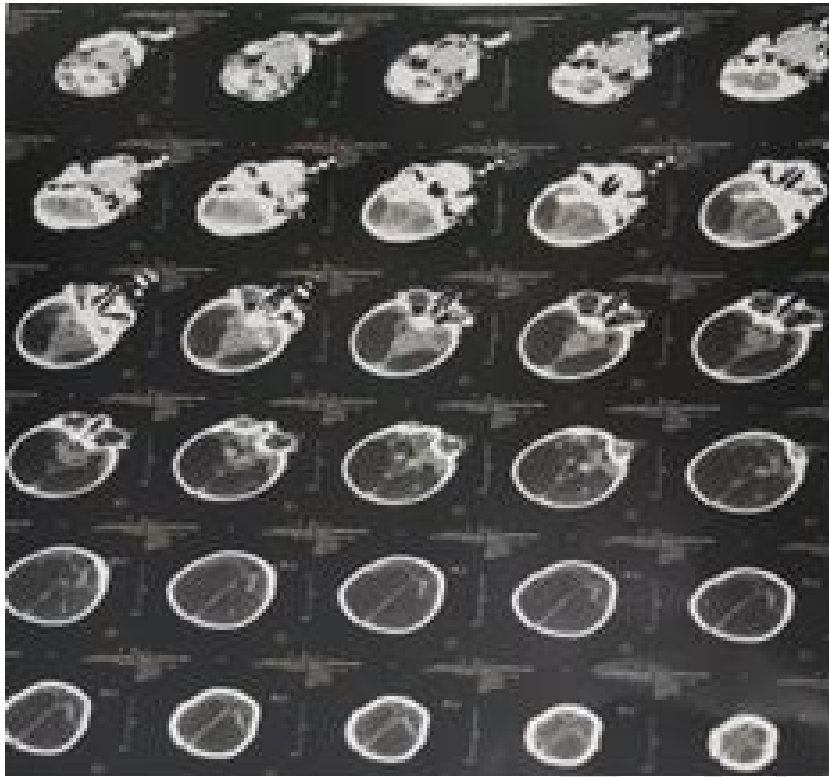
Brain CT of our patient: significant hydrocephalus laminating the brain parenchyma
